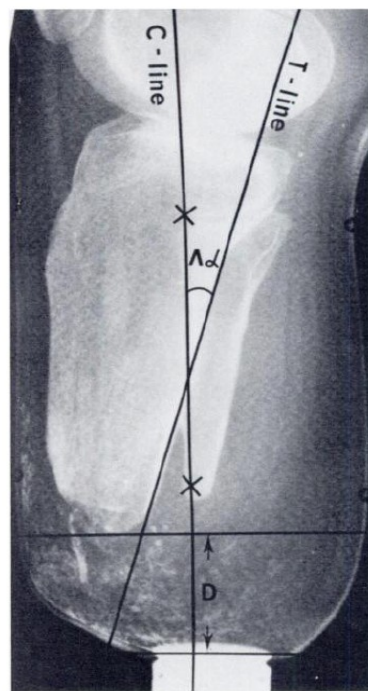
Measuring the tibia vertical movement by radiographic method (Grevsten & Erikson, 1975).
